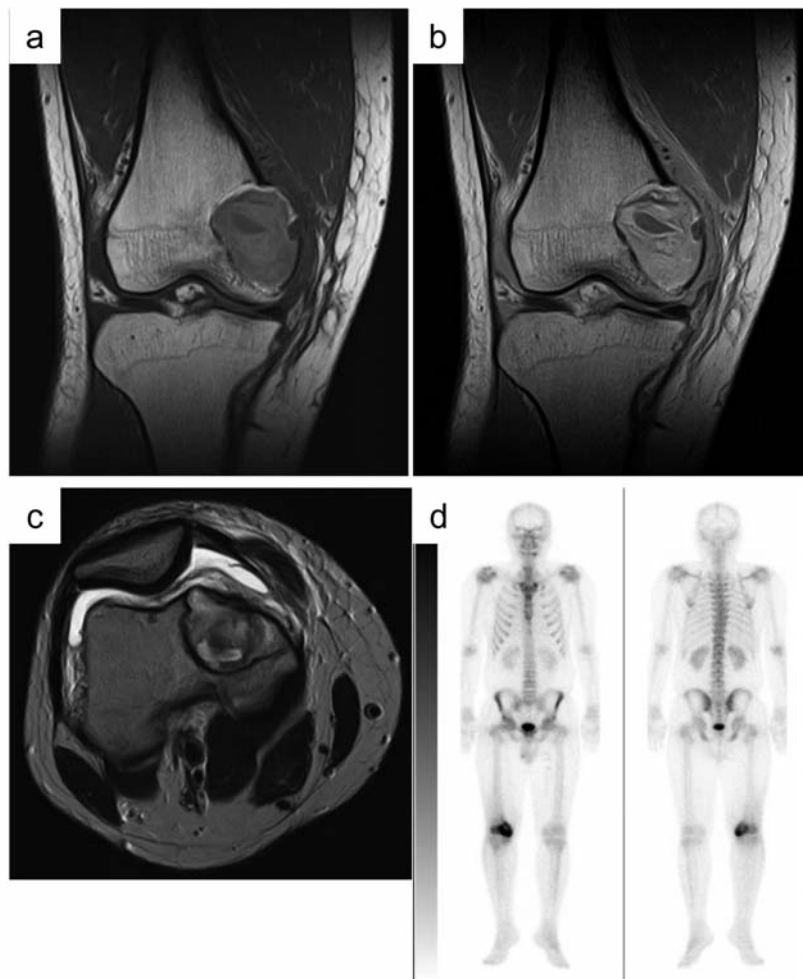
a: Coronal T1-weighted magnetic resonance imaging (MRI) (TR 675 ms, TE 15.7 ms) scan revealing mixed low- and iso-intensity. b: T2-Weighted MRI (TR 4500 ms, TE 106 ms) images showing areas of mixed low- and high-intensities. c: Axial T2-weighted MRI (TR 4500 ms, TE 106 ms) showing areas of mixed low and high-intensity. No abnormal soft tissue mass can be seen. d: Bone scintigram ( $^{99m}$ -technetium) showing areas of high accumulation in the right distal femur.
